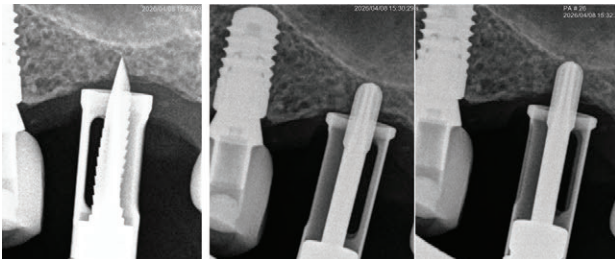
On the left the lance/guide drill is shown at 2mm to start the process of measuring during drilling. The CBCT showed 3mm of bone below the sinus and the 2mm sharp drill was safe enough to use, whereafter the 3mm drill (middle) takes the process to the sinus floor and the 4mm drill (on the right) starts perforating the sinus floor in a controlled manner with drills not cutting at the tip.
